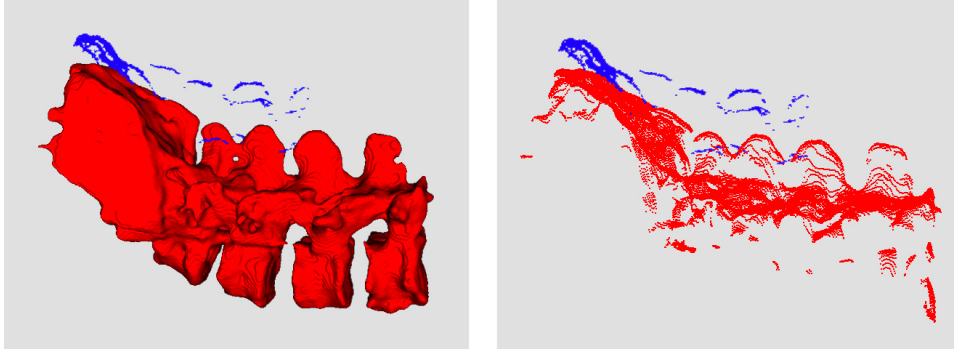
The segmented ultrasound (blue) and MR (red) surfaces (left) and the same surfaces after reducing the MR surface with ray tracing (right).
